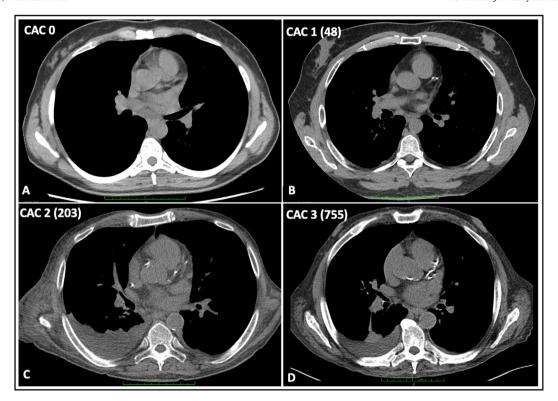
Representative example of the different coronary artery calcium (CAC) categories at standard chest computed tomography. A: No coronary calcium (CAC = 0); B: Mild coronary calcifications (CAC = 48); C: moderate coronary calcifications (CAC = 203); D: severe coronary calcifications (CAC = 755).
